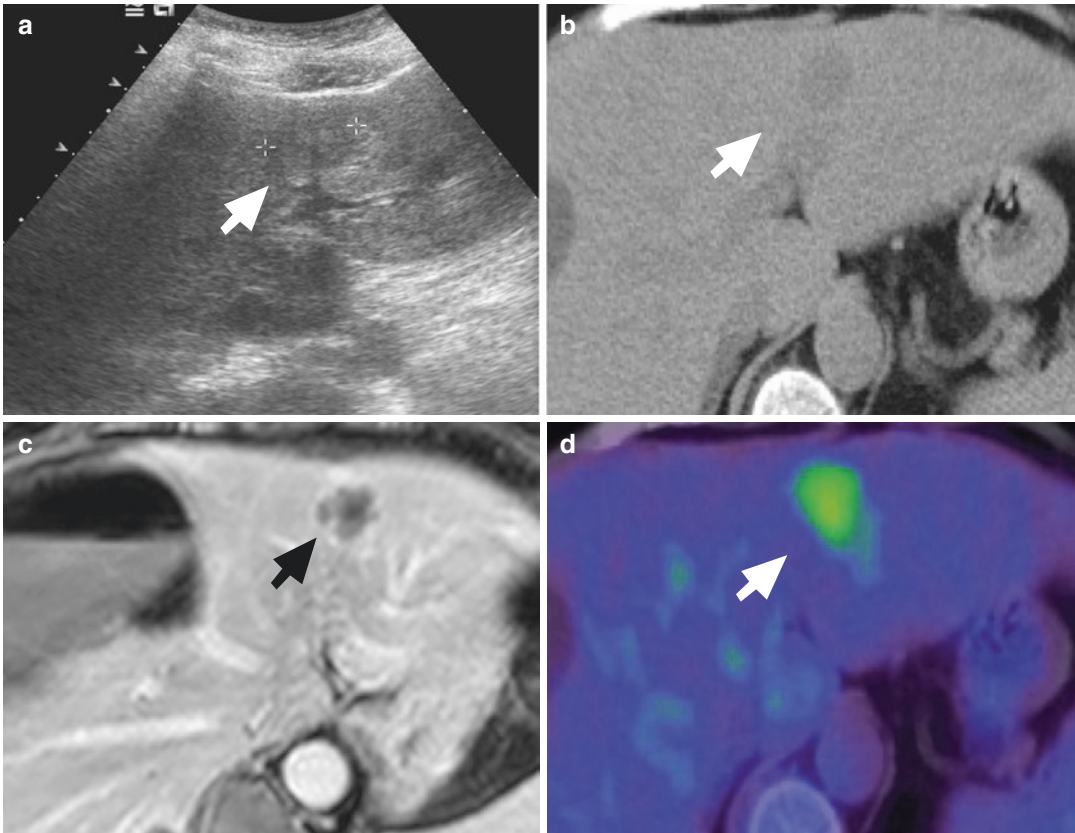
The same CLM in different imaging modalities (*arrow*). Inhomogenous hypoechogenicity in US (a). Hypodense to surrounding liver in unenhanced CT (b).
